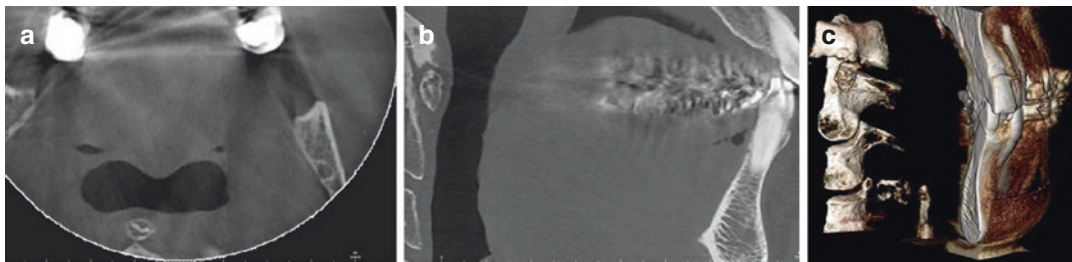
Axial (a), coronal (b), and midsagittal (c) CBCT images of a 62-year-old woman referred for implant site assessment. Her medical history reveal with moderate neck pain and incidental findings showed a “halo” like calcification superior to the odontoid process. Note the associated posterior osteosclerosis and thickening of the cortex of the odontoid process of C2.
